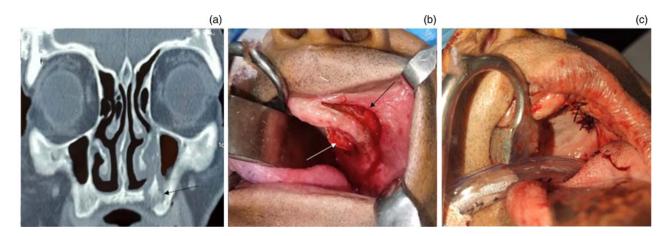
Case 2. (a) Coronal plane contrast-enhanced computed tomography of the nose, paranasal sinuses and orbit. Black dotted arrow indicates left-sided hard palate erosion. (b) Intra-operative image (edentulous patient). White arrow indicating palatal flap. Black arrow indicating gingivolabial flap. (c) Intra-operative image after closure.
